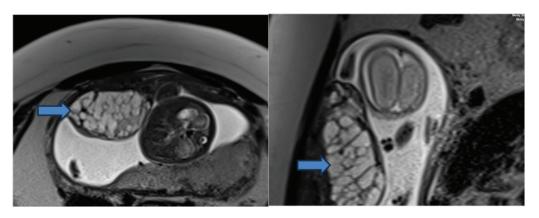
MRI images of placental mesenchymal dysplasia
